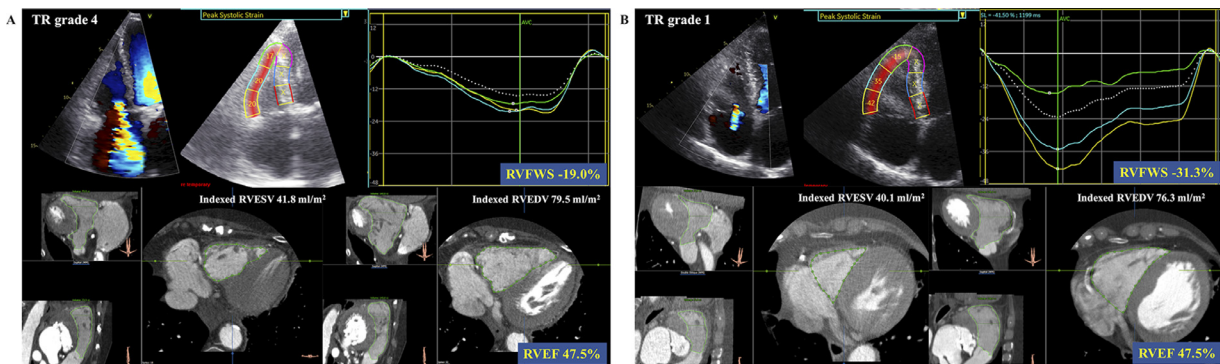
Representative examples of right ventricular systolic function assessment in a patient with severe tricuspid regurgitation (A) and a patient with trivial tricuspid regurgitation (B). Although these patients had comparable right ventricular volumes and ejection fraction on multidetector row computed tomography, the patient with severe tricuspid regurgitation had more impaired right ventricular-free wall longitudinal strain than the patient with trivial tricuspid regurgitation. RVEDV = right ventricular end-diastolic volume; RVEF = right ventricular ejection fraction; RVESV = right ventricular end-systolic volume; RVFWS = right ventricular free wall longitudinal strain; TR = tricuspid regurgitation.
